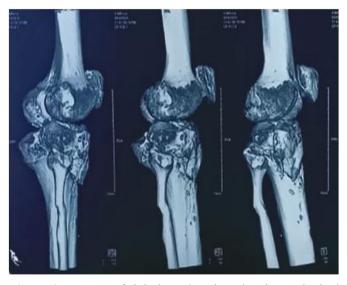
CT scan of right knee 3D view showing malunited proximal tibia fracture with secondary advanced osteoarthritis
